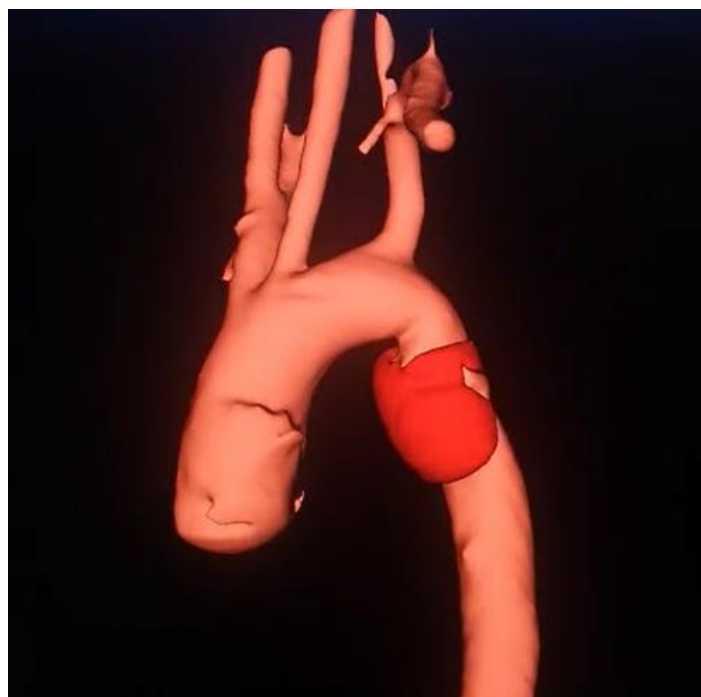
3D reconstruction of computed tomography angiography (CTA) of the thoracic aorta before TEVAR, showing a large descending thoracic aneurysm involving the aortic arch and proximal descending segment
